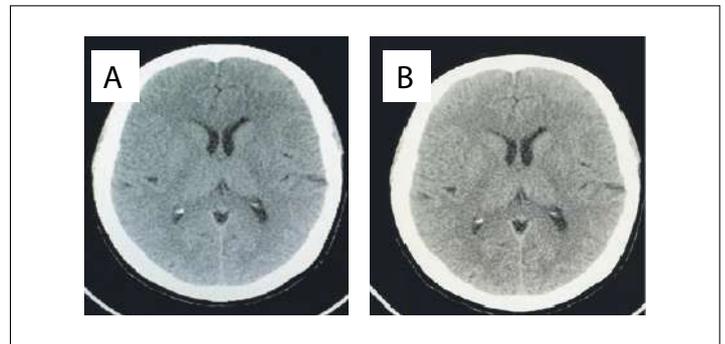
Computed tomography scans: 1A) preoperative; 1B) postoperative.
